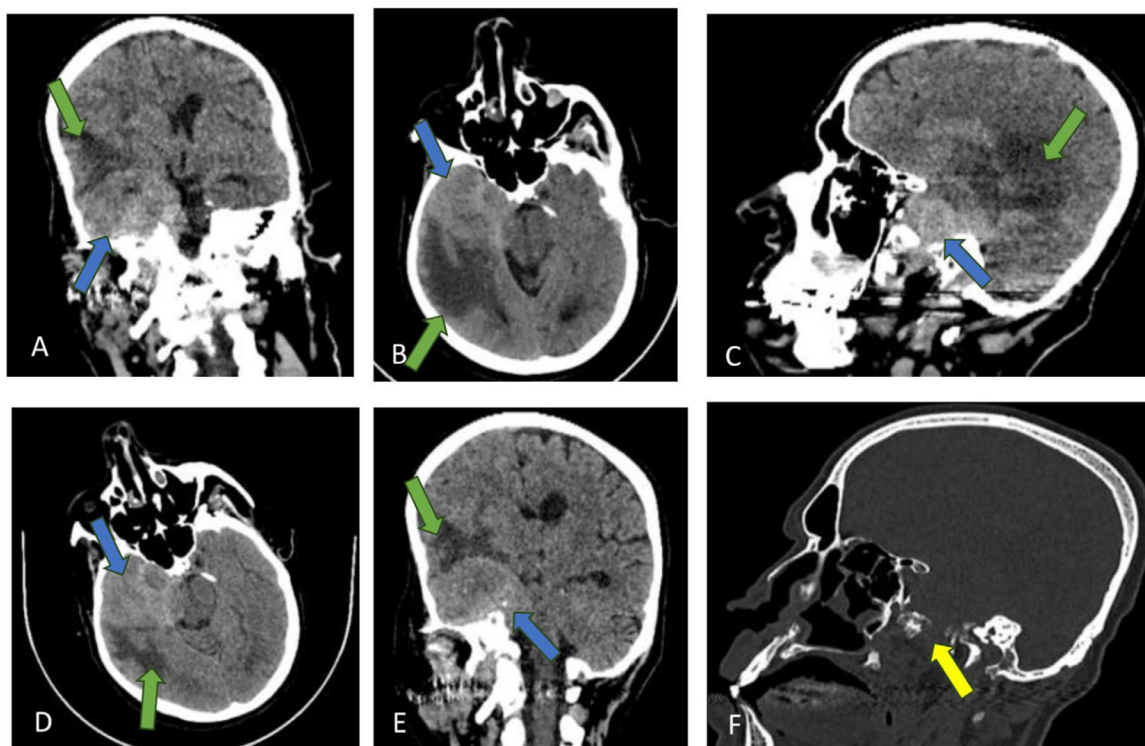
Follow up brain CT without contrast after 5 months in multi planes presented in brain (A-E) and bone (F); (A-E) Showed enlargement of previously noted intracranial extension of right parotid tumor at the right temporal region (blue arrow) with newly developed perifocal vasogenic edema (green arrow). (F) Bone destruction at right greater wing of sphenoid (yellow arrow).
